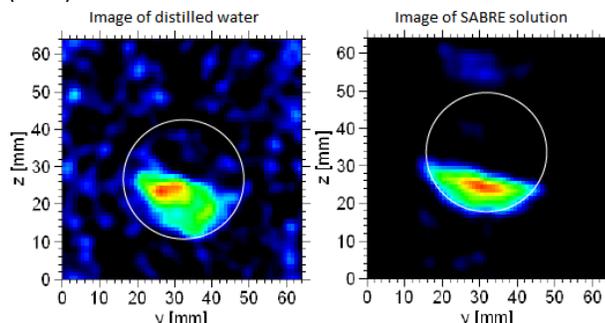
2D projection spin-echo MRI of distilled water (left, 6 ml, N=32, 2h 16' 32'') and hyperpolarized pyridine (right, 3 ml, N=1, 4min 16s). White circles indicate the reaction chamber (FOV 64 mm², matrix size 32², 1x zero fill., interp. resolution 1 mm², TE 150 ms, TR 8 s).
